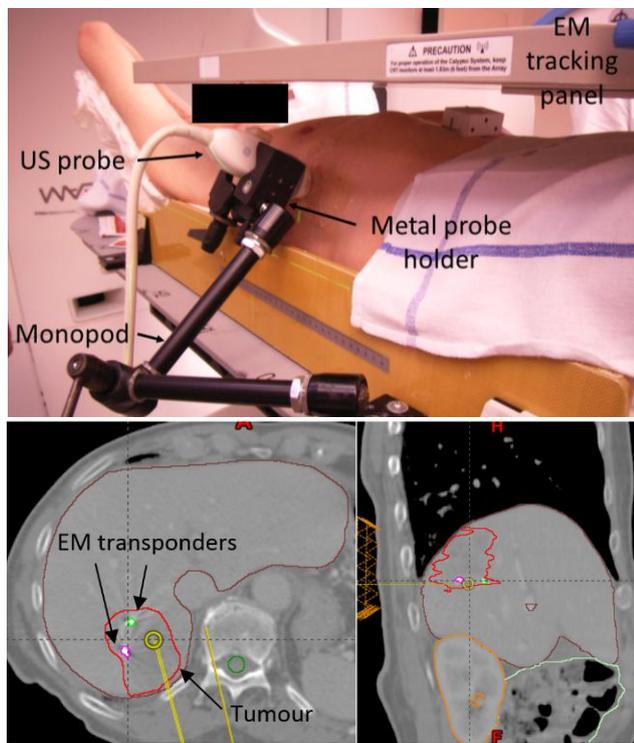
Top – Setup for simultaneous acquisition of 4D ultrasound imaging and electromagnetic tracking. The ultrasound probe was attached to the patient couch to continuously visualize the target region. Bottom – Two (out of three) implanted transponders in the liver surrounding the tumour.
